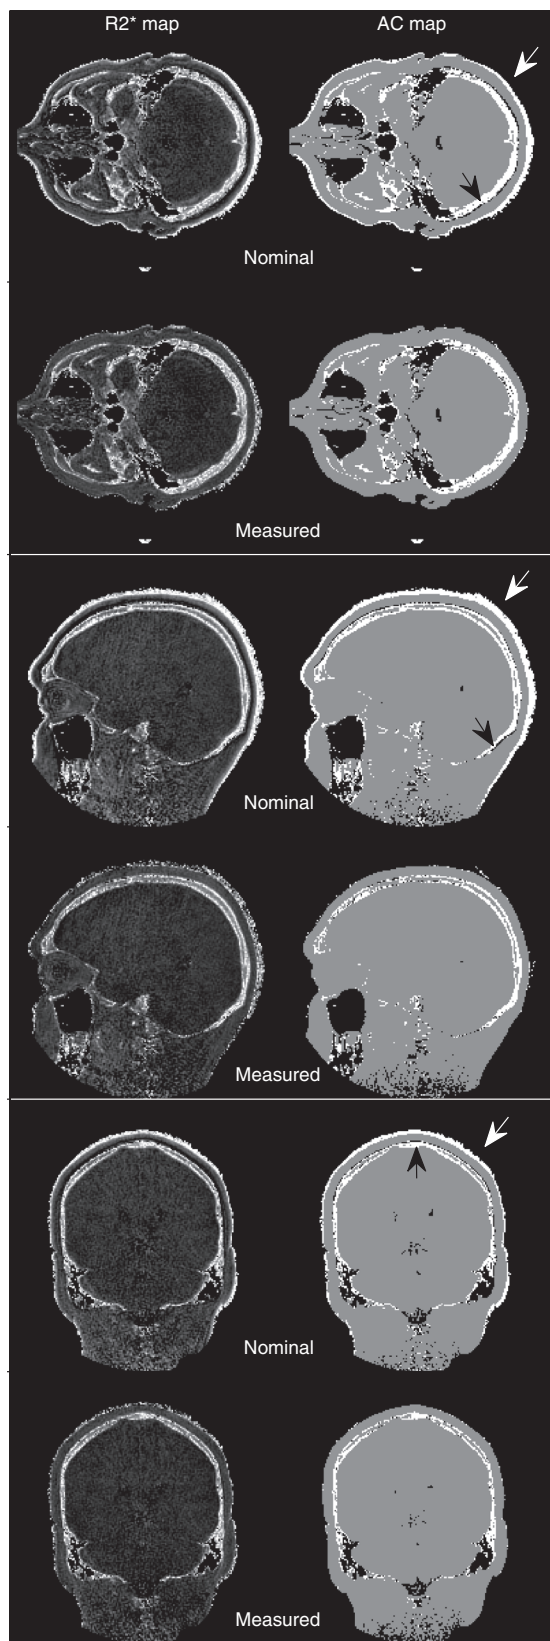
Axial, sagittal, and coronal slices from 3D  $R_2^*$  maps and segmented AC maps derived from cranial UTE MRI scans of a second volunteer reconstructed using nominal k-space trajectories and again with measured trajectories. Black arrows show hypointense artifacts on the bone–soft tissue border, leading to misclassification of bone as air in nominal AC maps. White arrows show hyperintense artifacts on the air–soft tissue border, leading to misclassification of soft tissue as bone in nominal AC maps.
